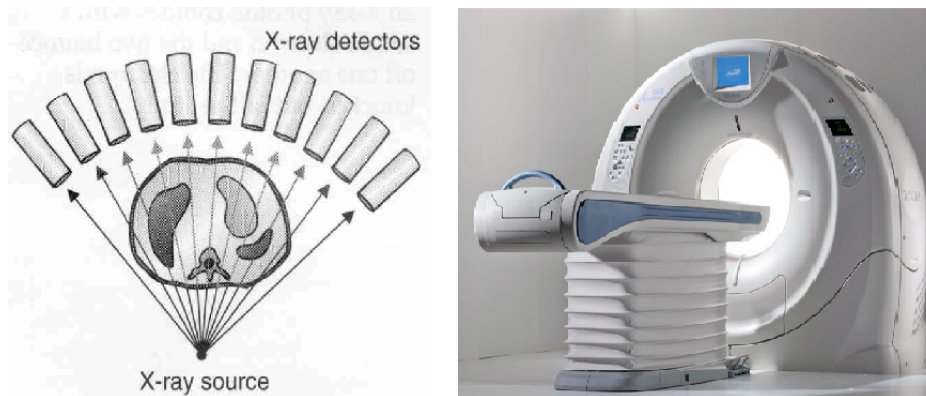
Computed Tomography Scanner
